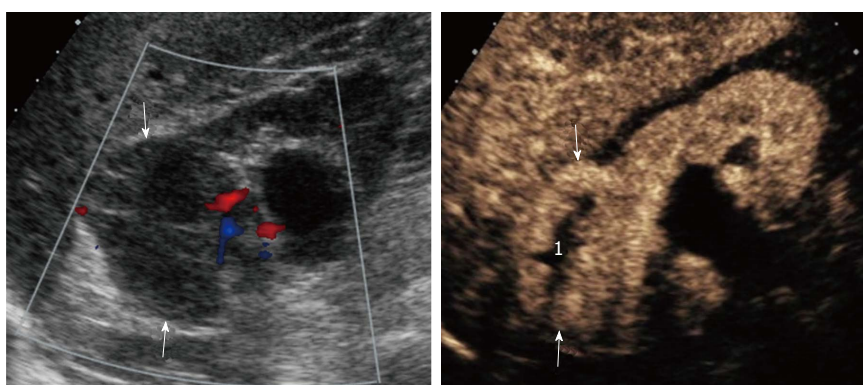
Patient with grade III chronic renal failure. A: Color Doppler ultrasound showed markedly reduced renal parenchyma perfusion and a hypoechoic lesion without obvious vascularity (arrows); B: Contrast enhanced ultrasound showed a solid enhancing mass (arrows) with avascular central portion (1). A clear cell RCC with necrotic central areas was found at surgery. RCC: Renal cell carcinoma.
